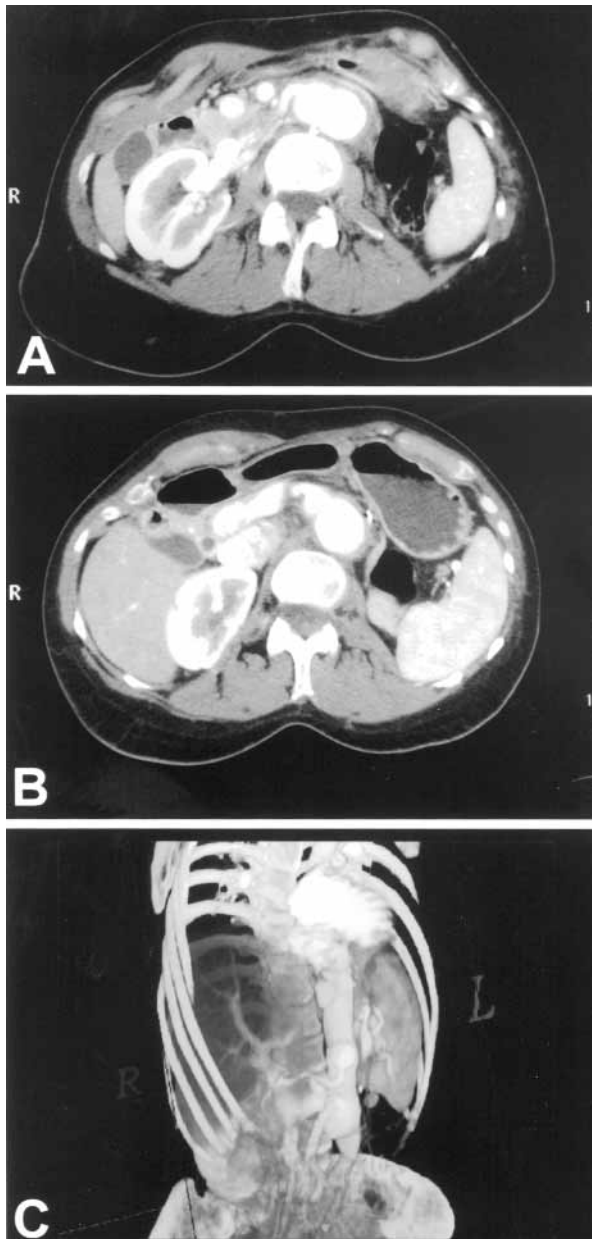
CT scans of patient with visceral patch aneurysm, unoperated. A, Patch aneurysm near right renal artery. B, Patch aneurysm near SMA. C, Three-dimensional CT scan rotation focusing on SMA and right renal artery orifices. *CT*, Computed tomography; *SMA*, superior mesenteric artery.
